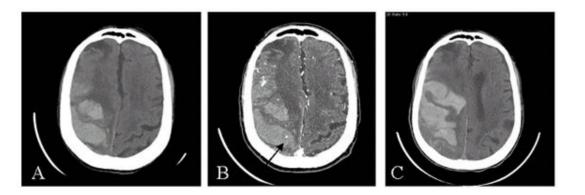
CT scans of an 83-year-old woman with acute onset of left-sided weakness. a Unenhanced CT with a right fronto-parietal hemorrhage. b CT angiogram showing normal cerebral vascular enhancement and punctate foci of intrahematomal contrast (one shown by *arrow*) with no clear vascular source. c Unenhanced CT performed 1 h later showing evidence of hematoma expansion. (Reprinted from Delgado Almandoz *et al* with permission.)
